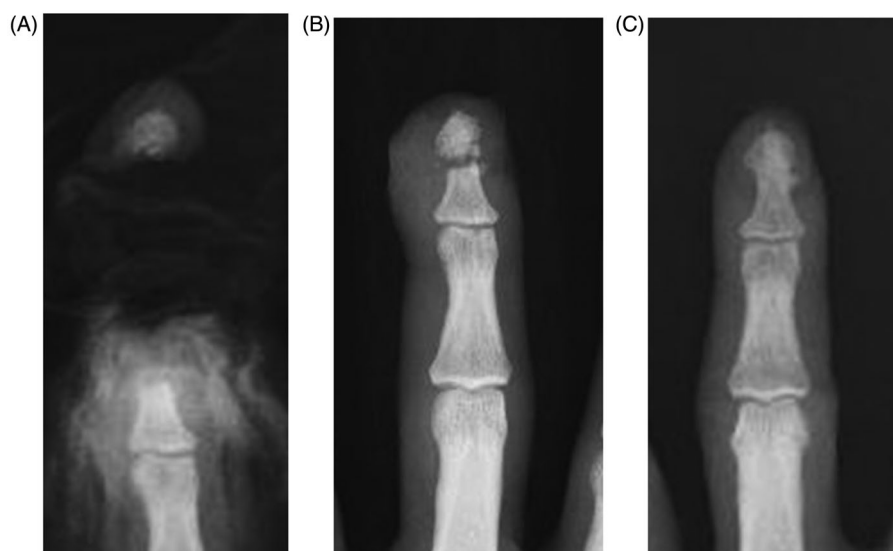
Case 9. (A) Anteroposterior X-ray view before replantation. (B) Anteroposterior X-ray view after replantation. (C) Anteroposterior X-ray view at 19 weeks after replantation. Complete bone union has been obtained.
